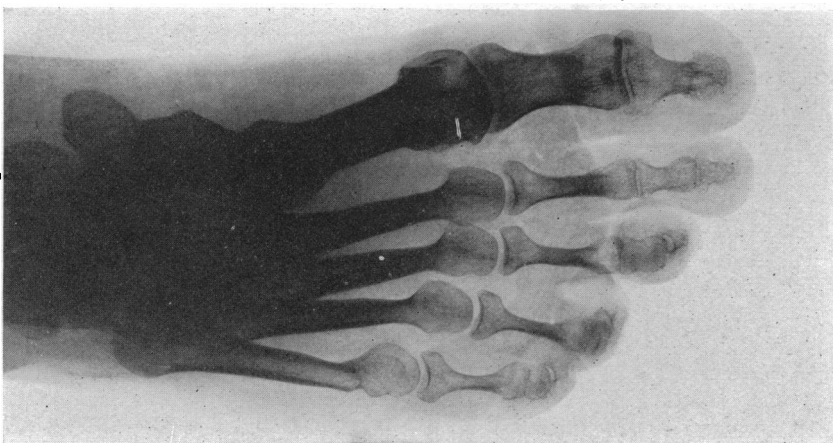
Follow-up roentgenogram of Fig. 5, after nine months showing firm union. Note the thin callus rounded off.
